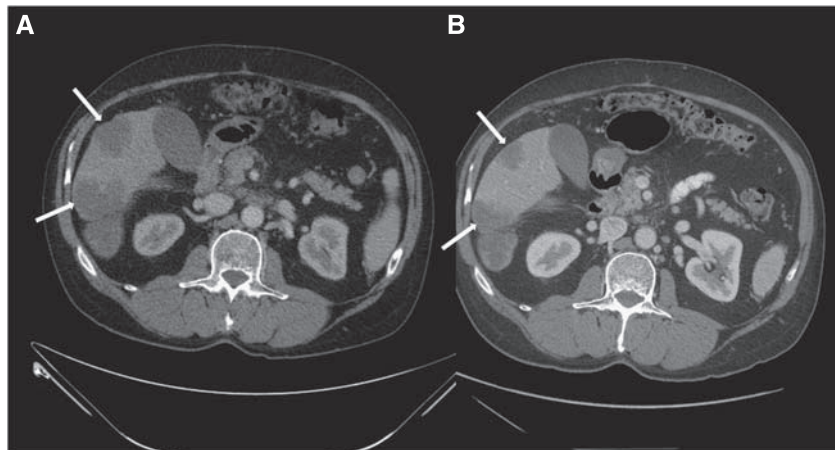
Pre-treatment (A) and post-treatment (B) computed tomography images showing radiographic response to single agent cetuximab in a patient with metastatic duodenal adenocarcinoma.
